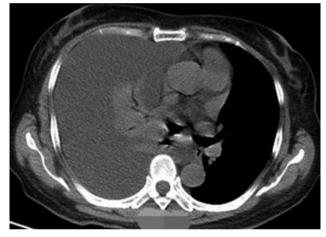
Chest computed tomography (CT) showing a large area of hydrothorax.
